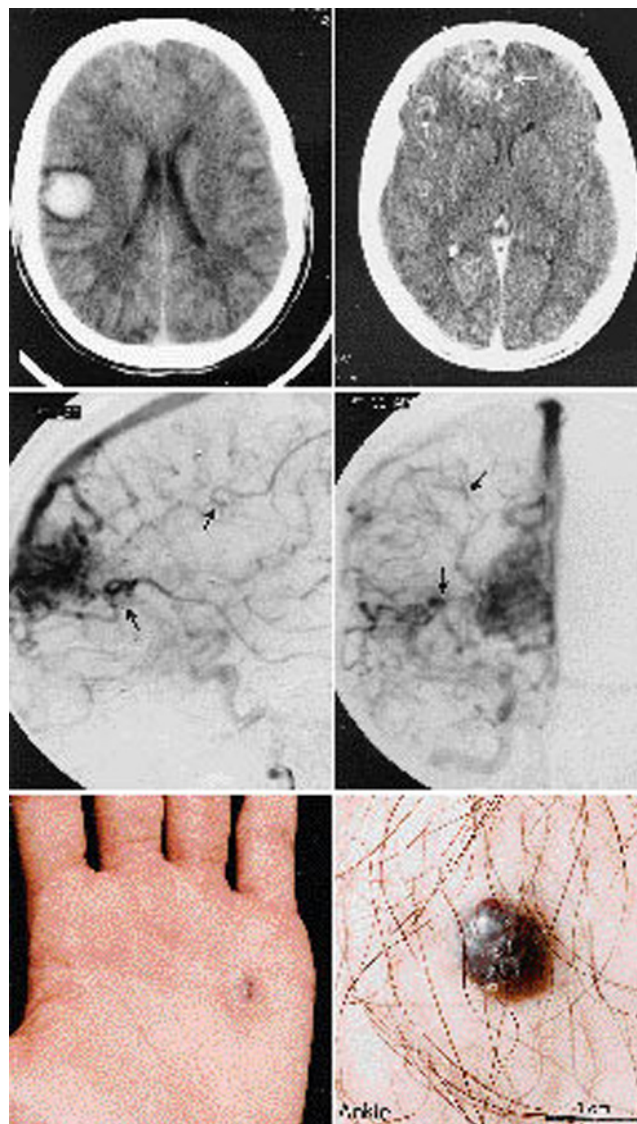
Case 1. Initial noninfused computerized tomography (CT) scans, carotid angiograms, and photographs showing vascular nevi. Upper: Computerized tomography scans demonstrating a right central intracerebral hematoma, a right frontopolar cerebral arteriovenous malformation (AVM) (large arrow), and an AVM in the right subopercular region of the frontal lobe (small arrow), both distant from the hematoma. Center: Right internal carotid artery angiograms demonstrating three cerebral AVMs. The largest is frontopolar where a large agglomeration of cerebral blood vessels is seen with shunting of blood through early draining veins. Two smaller AVMs with early draining veins are indicated by the arrows. The smallest AVM is the one that produced the cerebral hematoma seen on the CT scans. Lower: Photograph of the patient's palm (left) revealing a subcutaneous lesion (approximately 0.75 cm in largest diameter) diagnosed as a cavernous hemangioma on the basis of inspection and palpation; photograph of the patient's ankle (right) demonstrates a similar lesion of similar size.
